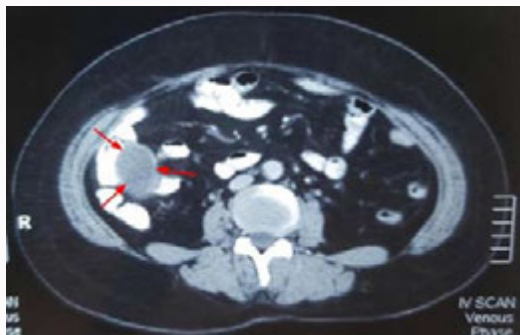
Axial view of the contrast-enhanced CT scan of the abdomen showing a well-defined non-enhancing cystic mass (red arrows) with a uniformly enhancing wall in the right iliac fossa.
